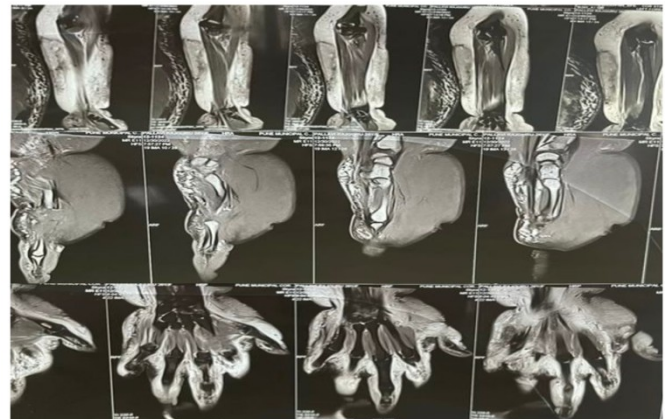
T2-weighted 3 Tesla MRI slice through the forearm and hand at 21 years of age, demonstrating hyperintense, lobulated subcutaneous soft tissue lesions without infiltration into musculature
